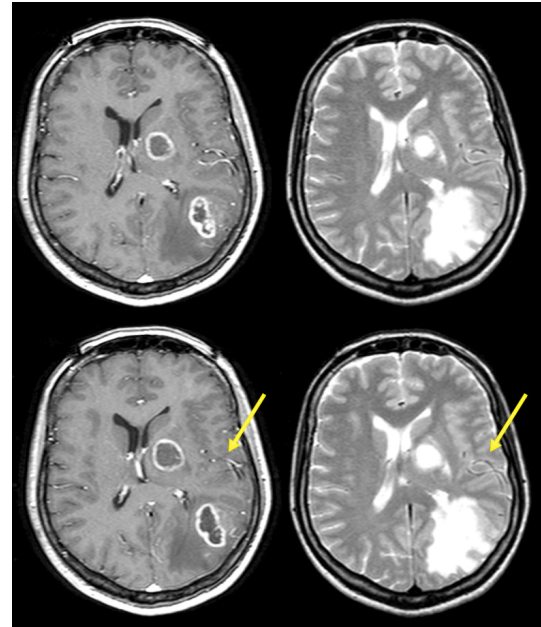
Two consecutive sets of slices: T1 contrast enhanced images on the left; T2 weighted images on the right. The arrows point to corresponding regions where the registration algorithm produces slightly misaligned results due to different slice thicknesses in MRI sequences.
